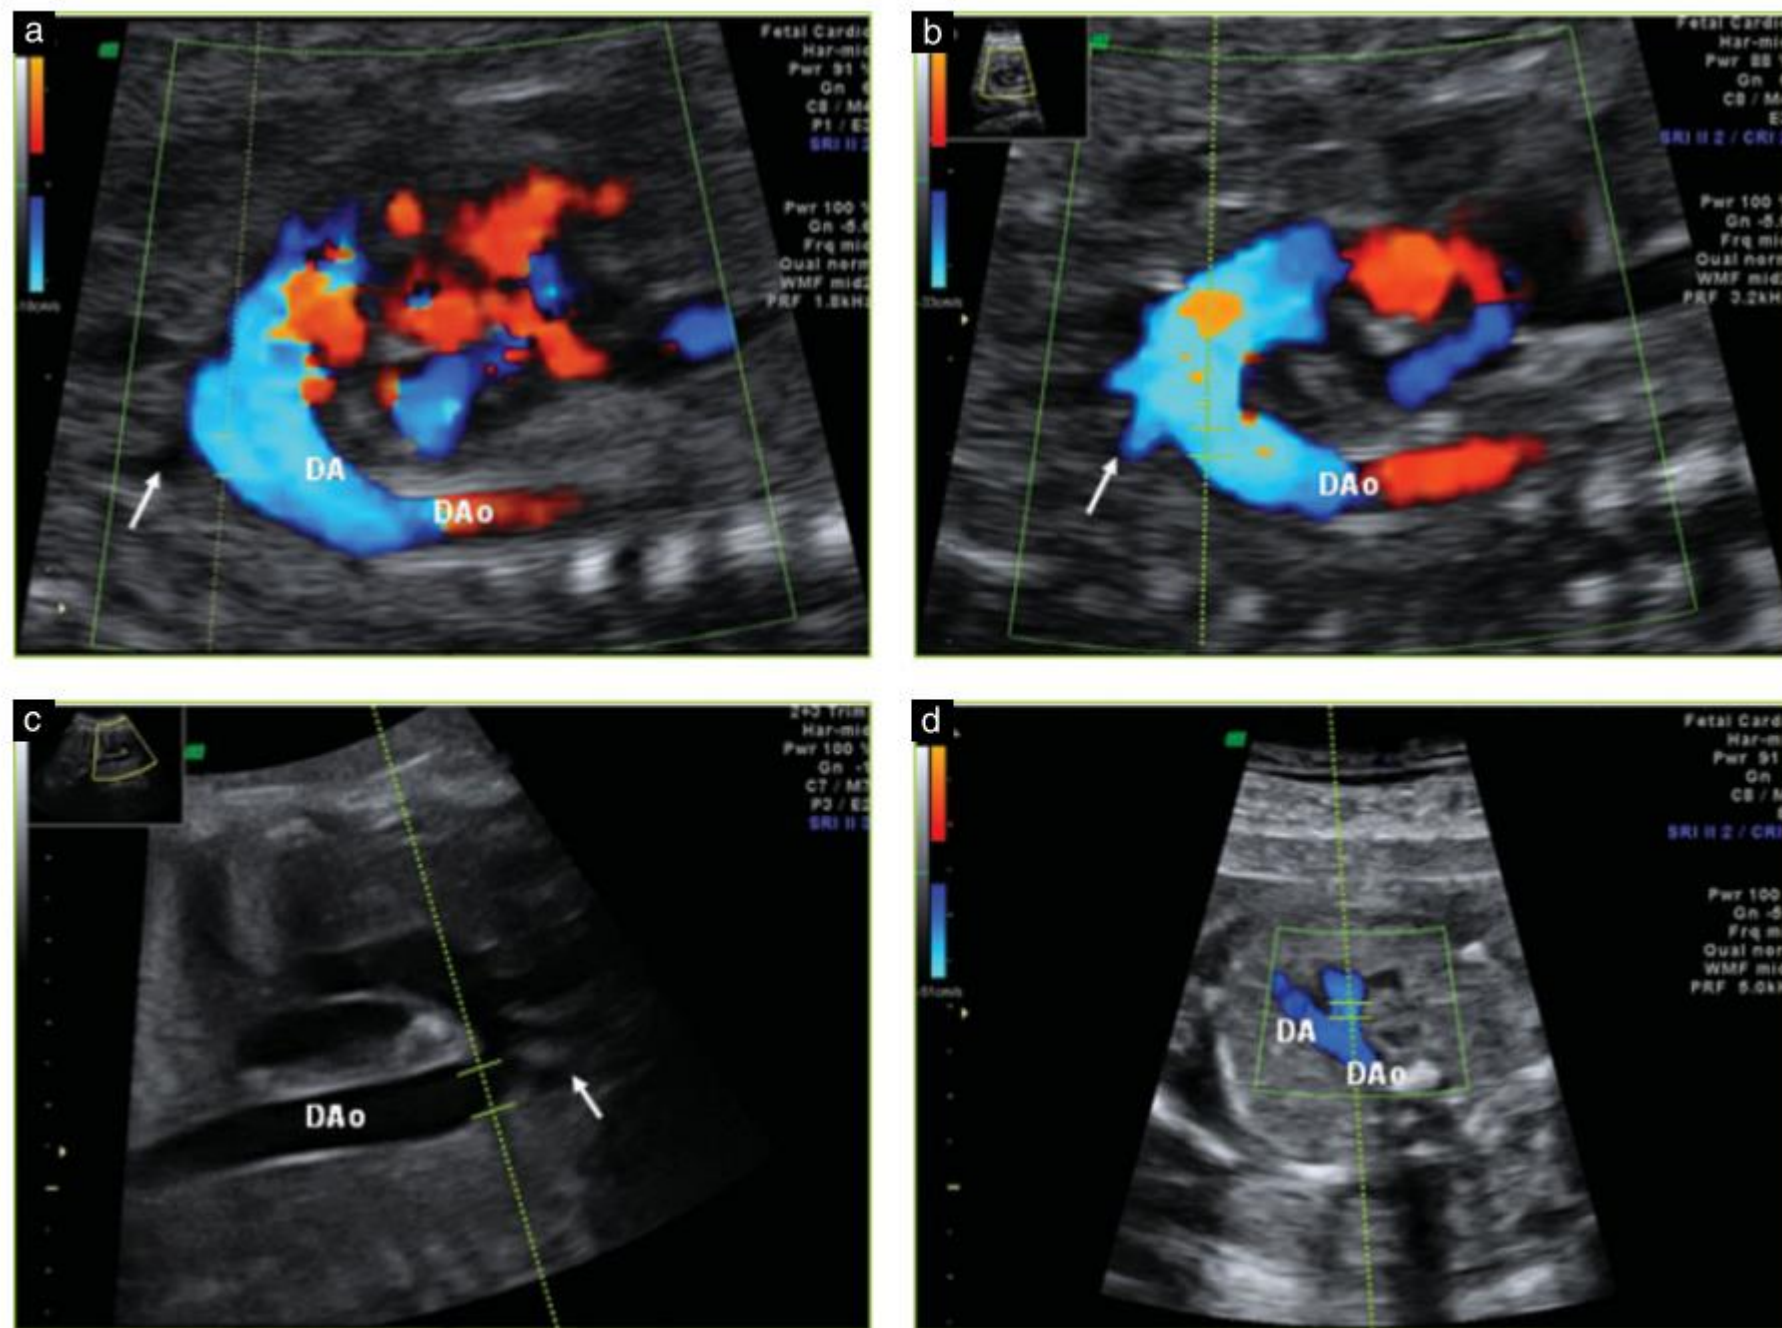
Longitudinal (a–c) and cross-sectional (d) imaging planes demonstrating the aortic isthmus with correct cursor placement for pulsed-wave Doppler interrogation. The arrow indicates the left subclavian artery. DA, ductus arteriosus; DAo, descending aorta.
